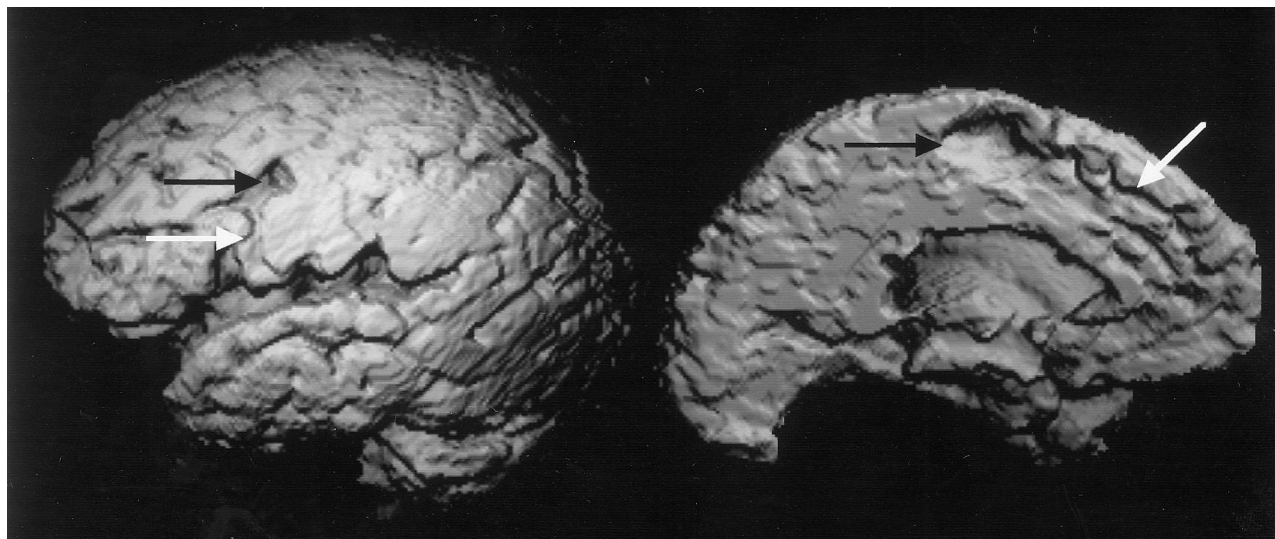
Patient 2: Lateral and medial surface reconstructions of automatically segmented brain sections from three-dimensional spoiled gradient-echo MR images (14/3/2/20° flip angle) of a patient with idiopathic NPH. Note the focally dilated, semiovoid-shaped sulci over the frontal convexity and medial surface (black arrows) and the narrow channels connecting dilated sulci with the sylvian fissure or basal cistern (white arrows), as well as the expanded sylvian fissure, the otherwise constricted convexity, and the medial surface sulci.
